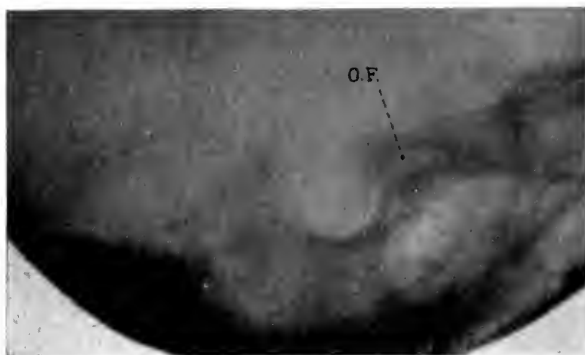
Case III. X-ray showing what was regarded as a normal sella with under-developed sphenoidal cells. Stereoscopically the characteristic undermining of the anterior clinoids from dilatation of the optic foramina is apparent at point indicated.
